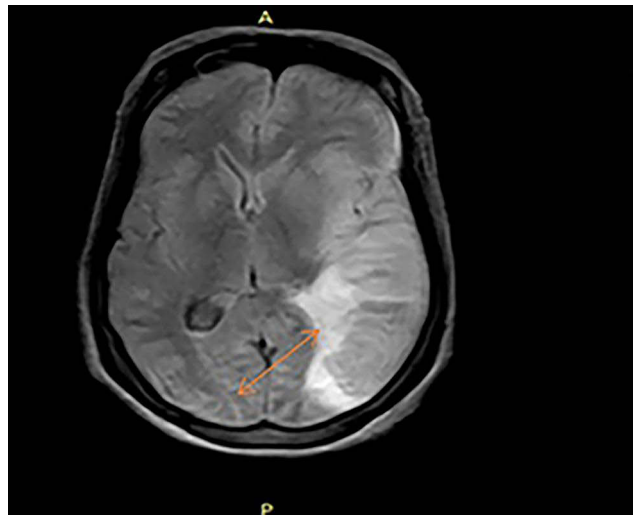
Sagittal non contrast brain CT scan show: Irregularly shaped hyper dense hemorrhage in the left parieto-occipital lobe on at grey white matter junction with surrounding hypo dense edema (Orange arrow).
